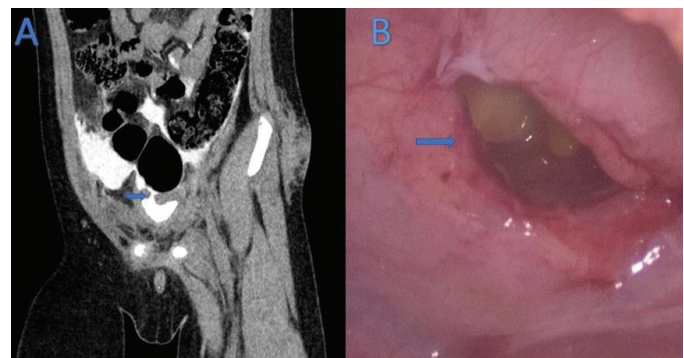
(A) CT-assisted cystography revealed of contrast medium extravasation from superiolateral aspect of bladder (arrow) (B) Laparoscopic view of the bladder wall defect (arrow)
